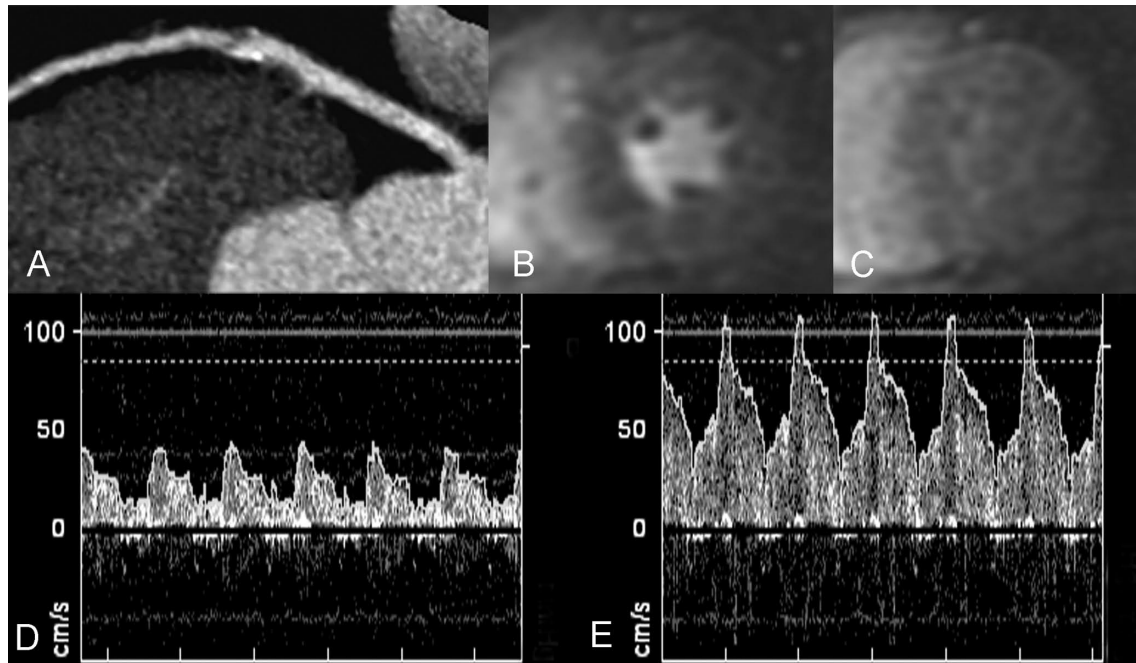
(A) CTCA image showing significant lesion in the mid-LAD. MR perfusion image during adenosine stress (B) and during rest (C) with normal perfusion of the myocardium in the perfusion territory of the LAD; the MPRI in this region was 2.3. CFR image of flow during rest (D) and during adenosine stress (E). The CFR in this patient was 2.6. CFR, coronary flow reserve; CTCA, computed tomography coronary angiography; LAD, left anterior descending; MPRI, myocardial perfusion reserve index; MR, magnetic resonance imaging.
